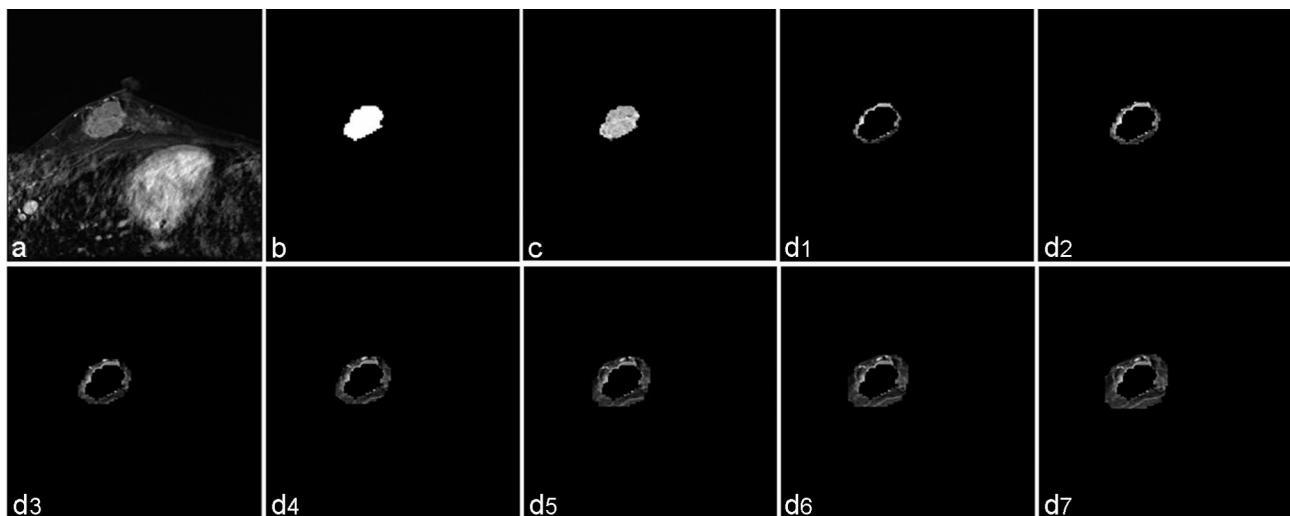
The MRI segmentation example: a Original image of breast cancer. b Tumor mask. c Tumor region in the MRI image. d Peritumoral tissue with different thicknesses (1–7 mm) in the MRI image. MRI, magnetic resonance imaging
